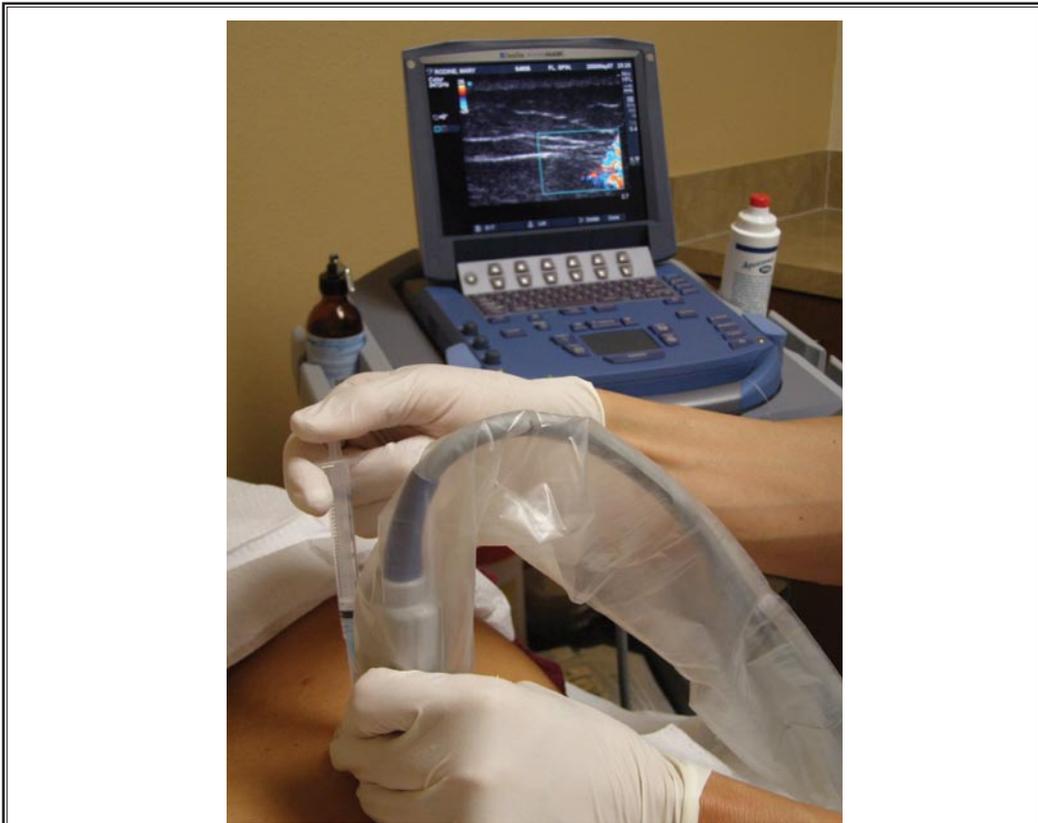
1.5-inch 25-gauge needle connected to 3 mL syringe is placed into the thoracic musculature utilizing continuous ultrasound guidance. The injectate can be seen spreading in the muscular tissue as seen in the color mode setting.*
